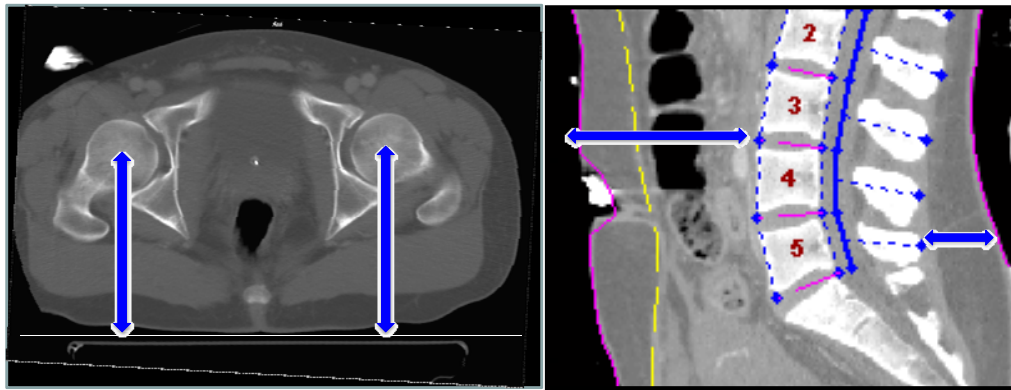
CT scan measurements including H-point (center of femoral head), vertebra-to-front skin and spine-to-back skin distance
